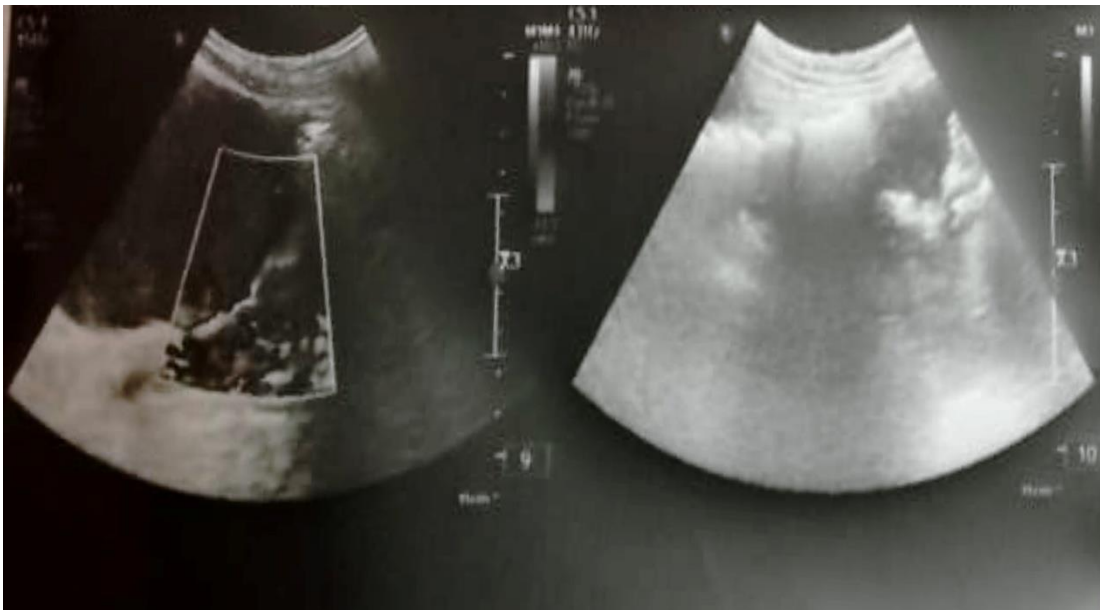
Ultrasonogram showing hepatosplenomegaly
